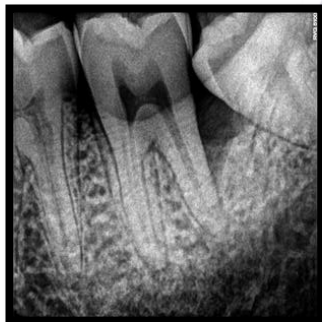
1year follow up radiograph(left mandibular second molar)
